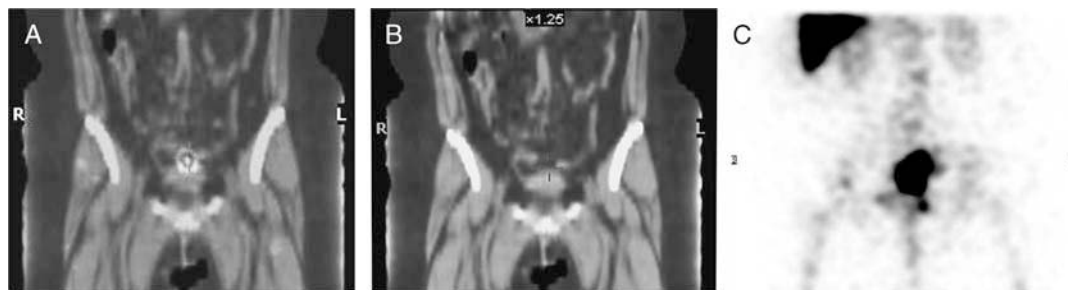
A, Case of SLN detection failure with low activity in SPECT/CT at the injection area after PT injection. B, The same case with CT alone. C, SPECT showing high activity in the liver and bone marrow. No SLN was detected.
